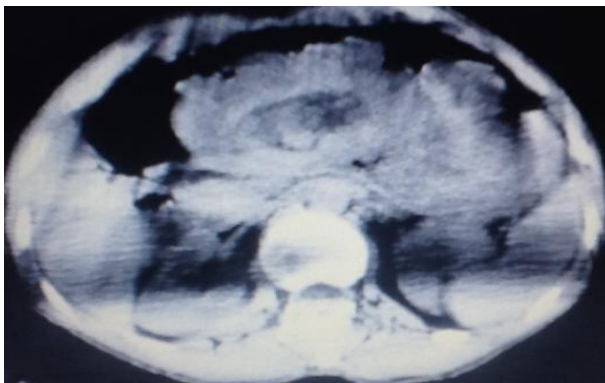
CT scan showing small bowel loops in Stomach
